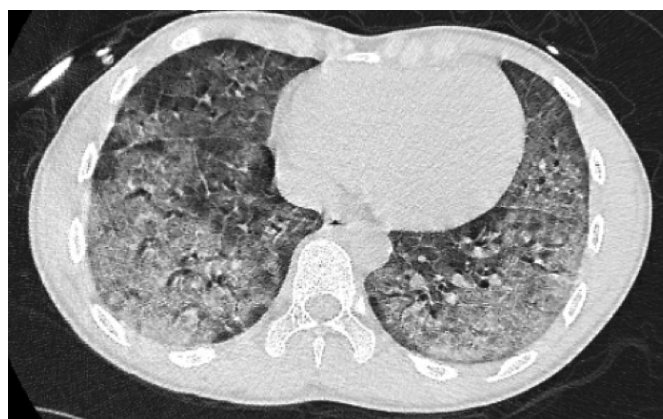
High Resolution Chest CT showing diffuse bilateral ground glass opacities predominantly involving the mid and lower lung zones.
